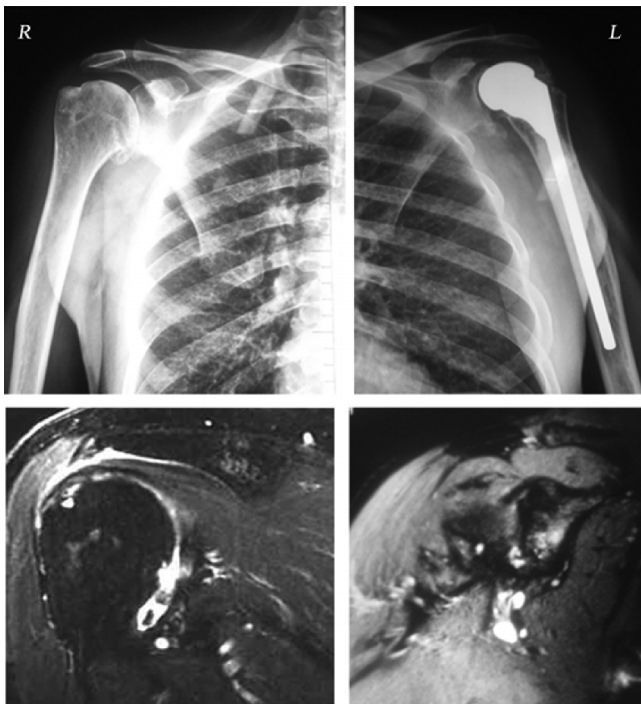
shows preop radiological evaluation with X rays and MRI. It shows X-ray right shoulder with narrowing of joint space. X-ray left shoulder shows hemiarthroplasty with implant insitu. MRI right shoulder showing evidence of synovial proliferation with small tiny loose bodies noted along the inferior part of head. Humeral head flattened with multiple osteophytes.
